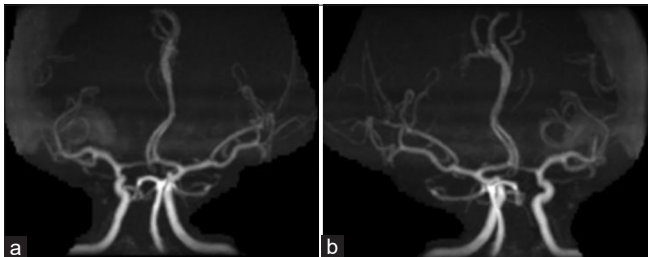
(a and b) Magnetic resonance imaging of brain vessels suggestive no luminal compromise
